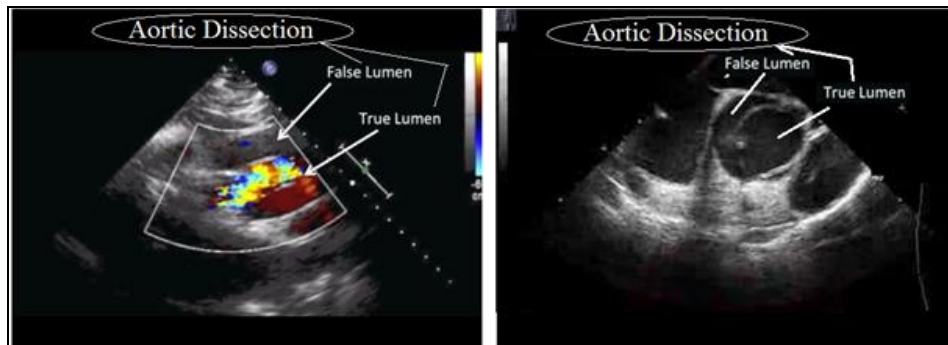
Echocardiogram showing left ventricular hypertrophy and ascending aortic dissection with pericardial effusion.
